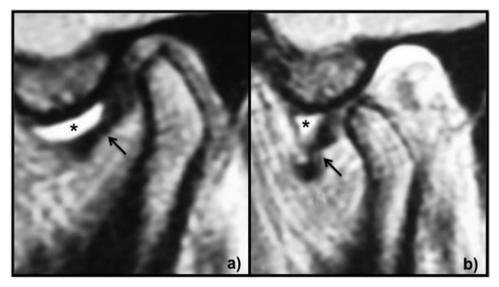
T2-weighted sagittal view: (a) mouth closed – note the presence of a hyper-signal area, characterizing effusion (asterisks), while the articular disc (hypointense area, arrow) is in a position prior to 11:30 h relative to the mandibular condyle; (b) mouth open – note the presence of flow, while the disc remains in the displaced position, characterizing disc displacement without reduction (DDWoR).
